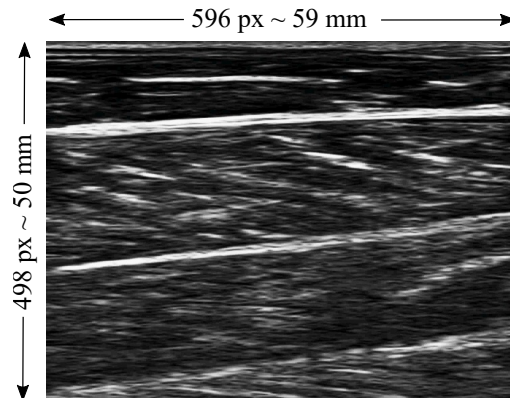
Dimensions of ultrasound frame in pixels (px) converted to physical distance in millimetres (mm). Adapted from [8].
